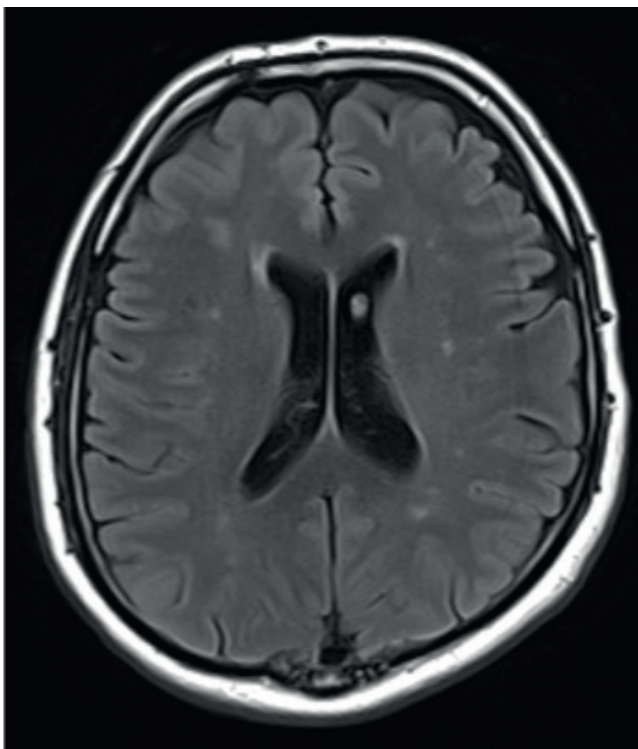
Gliotic foci with a tendency to coalesce in periventricular white matter in MRI
